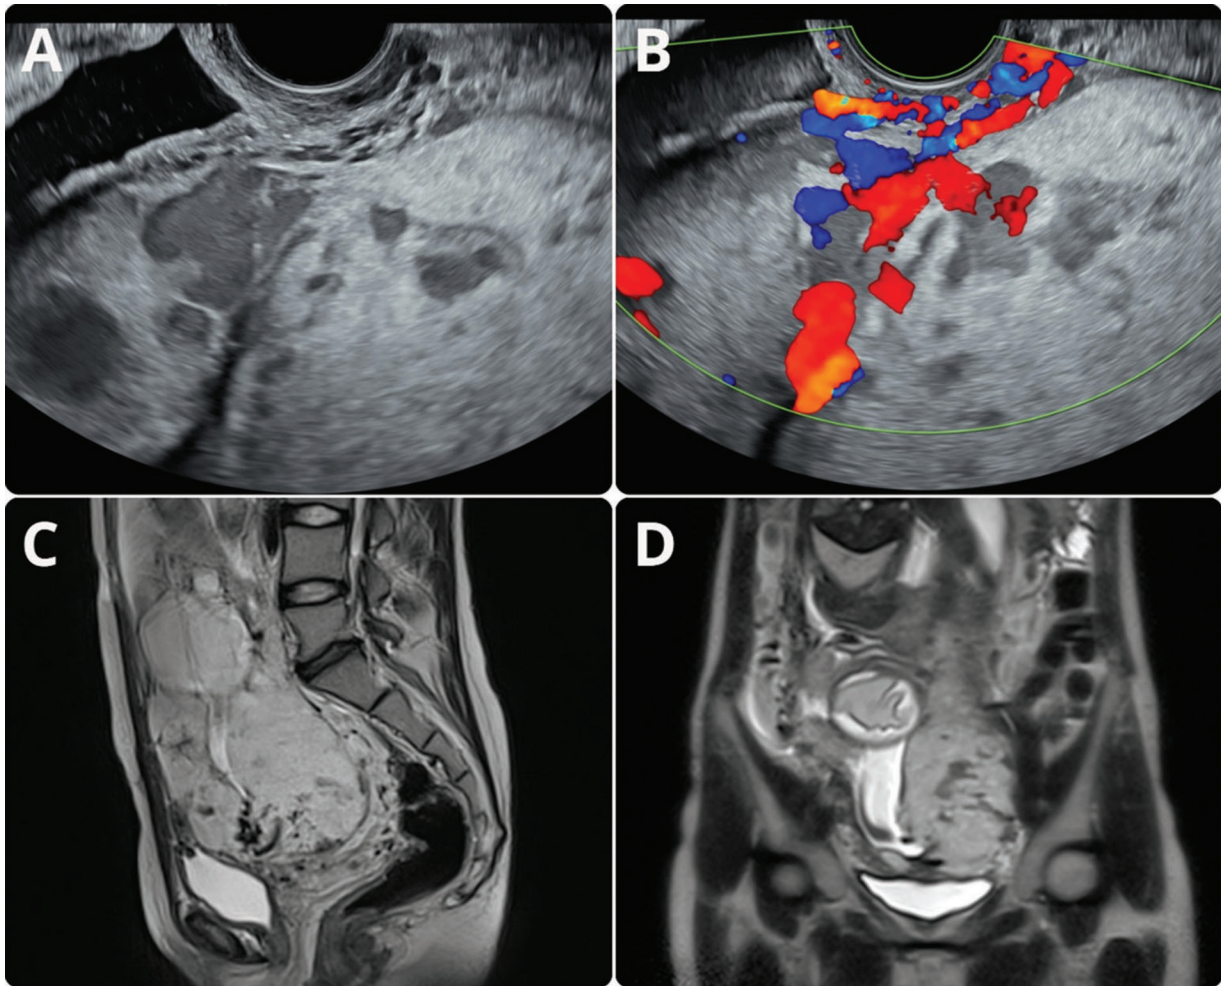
Imaging examination of a 20-year old patient with praevia PAS; A. Presence of numerous abnormal placental lacunae, undetectable myometrium and bladder wall interruption on grayscale ultrasound; B. Doppler mode showing vascular supply; C, D. T2- weighted MRI sequences (sagittal and coronal) confirming the diagnosis
